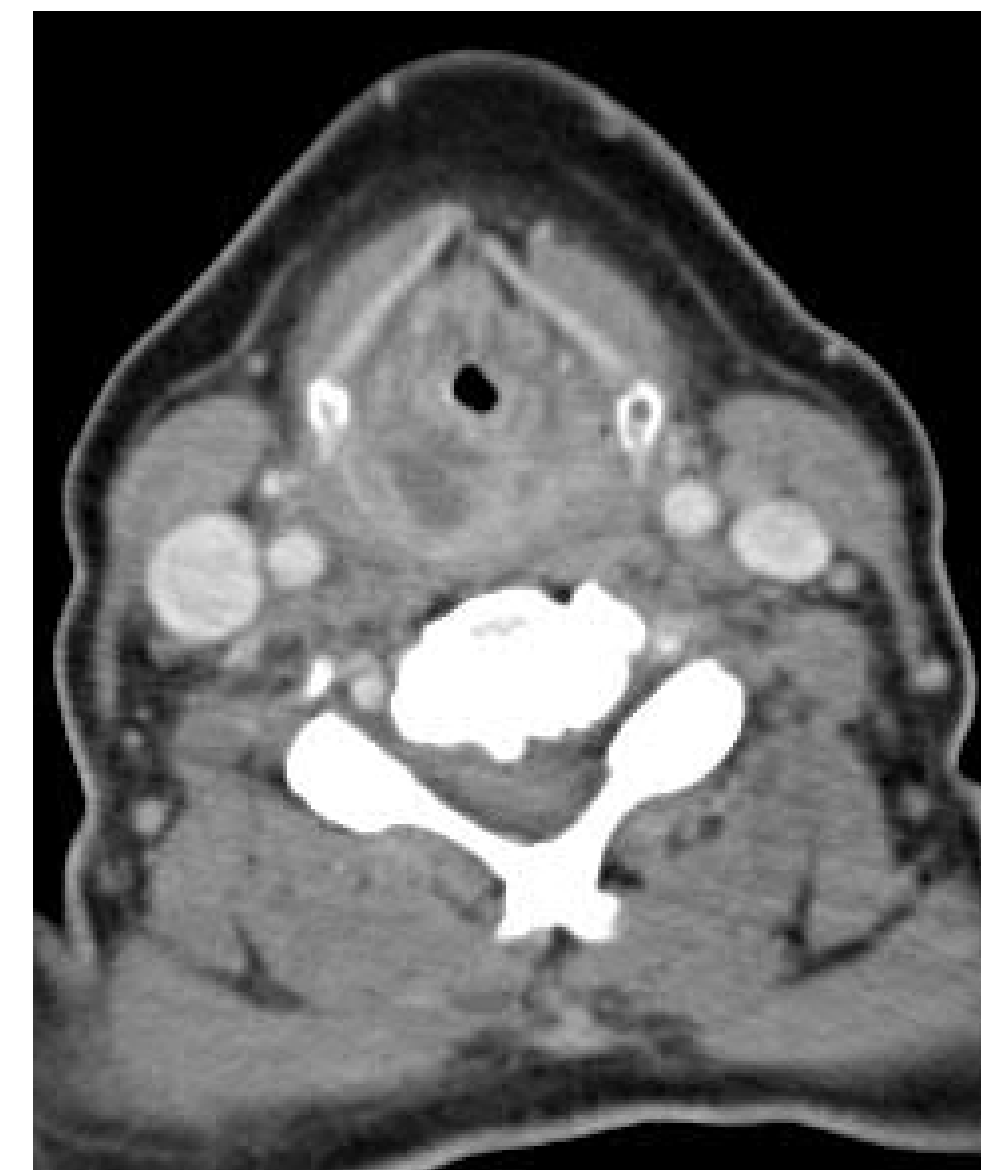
Axial CT image depicting the laryngeal abscess.
